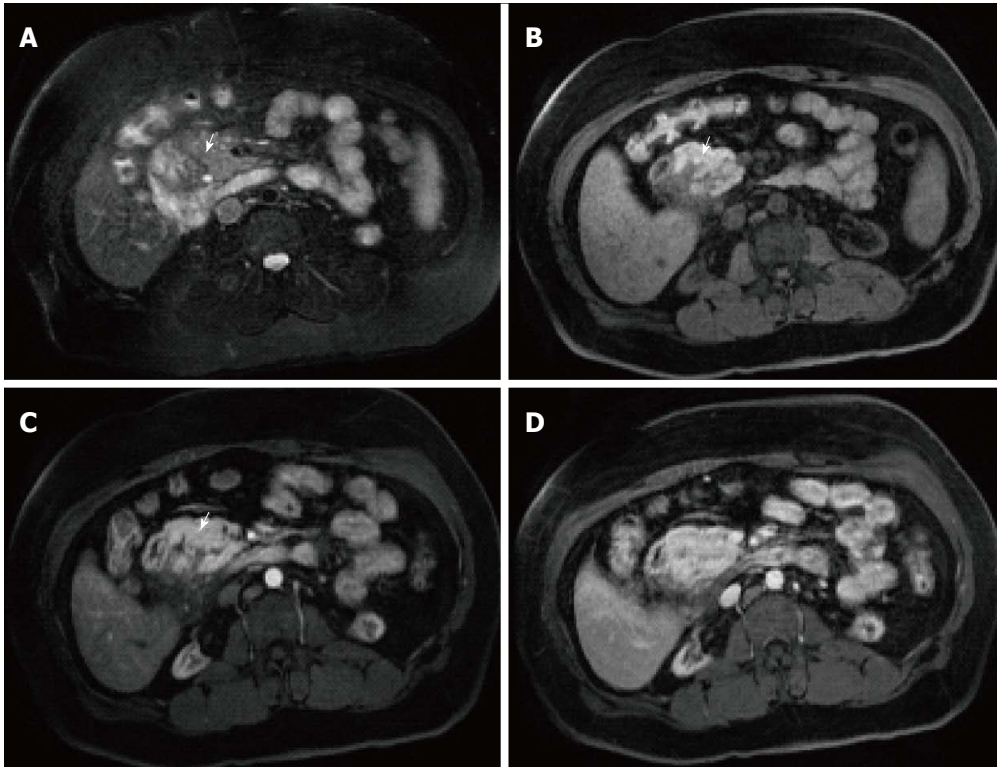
Groove pancreatitis. A: Axial T2-weighted single-shot fast spin-echo (SS-FSE) images with fat-suppression; (B) Pre- and (C, D) Post-contrast 3D-GRE T1- weighted images with fat-suppression during the late arterial and portal venous phases. There is a slightly low T2 signal sheet-like mass in the pancreaticoduodenal groove, with tiny cystic changes (arrow, A). The mass shows low T1 signal with extension into the pancreatic head (arrow, B). Imperceptible enhancement is depicted on the immediate post-contrast image (arrow, C), with progressive enhancement on the subsequent delayed images (D) in keeping with groove pancreatitis.
